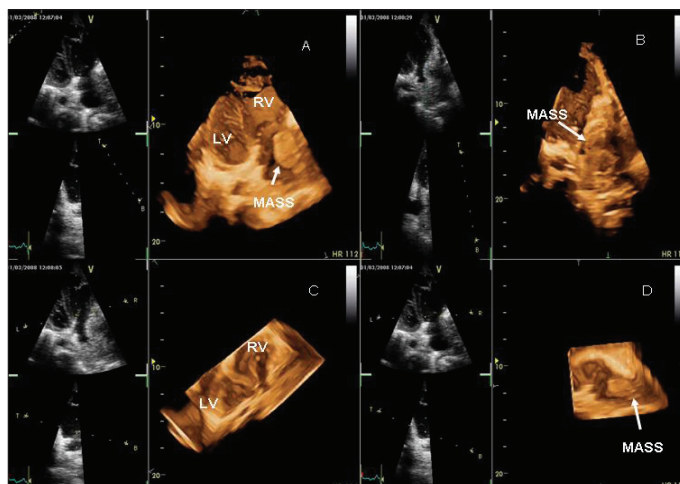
A-D) A three-dimensional echocardiogram showing mass in the right atrial cavity B) Frontal plane sections of the mass viewed en face, also demonstrating multiple echolucent areas C) Transverse plane section of the mass
